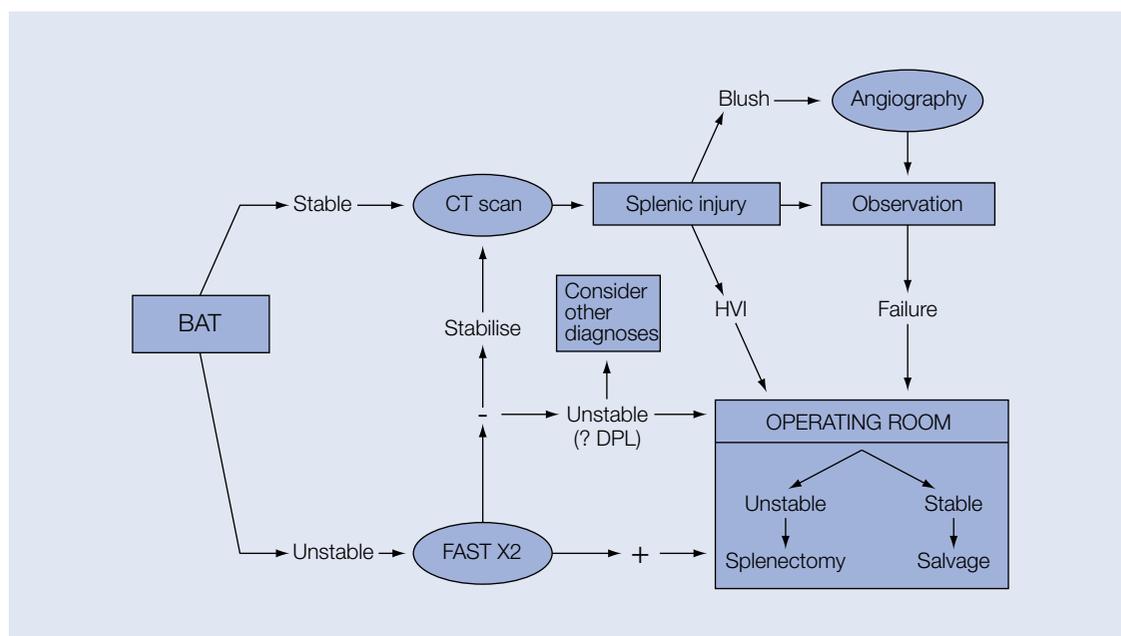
Current algorithm for suspected blunt splenic trauma BAT, blunt abdominal trauma; CT, computed tomography; FAST, focused abdominal sonography for trauma; HVI, hollow viscus injury; DPL, diagnostic peritoneal lavage; blush, extravasation of intravenous contrast
